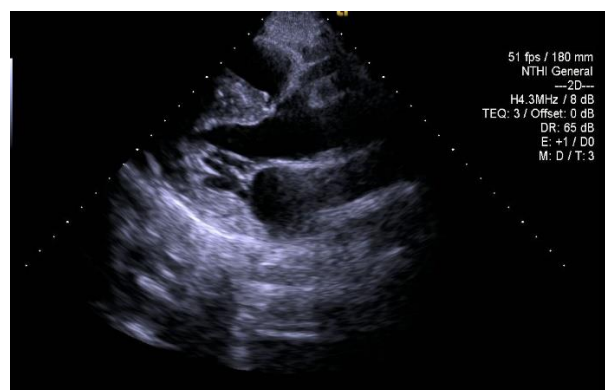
The 2D echocardiography, in the parasternal long-axis view, shows a dilated right coronary artery, which is a sign of anomalous left coronary artery from the pulmonary artery (ALCAPA) in echocardiography.
